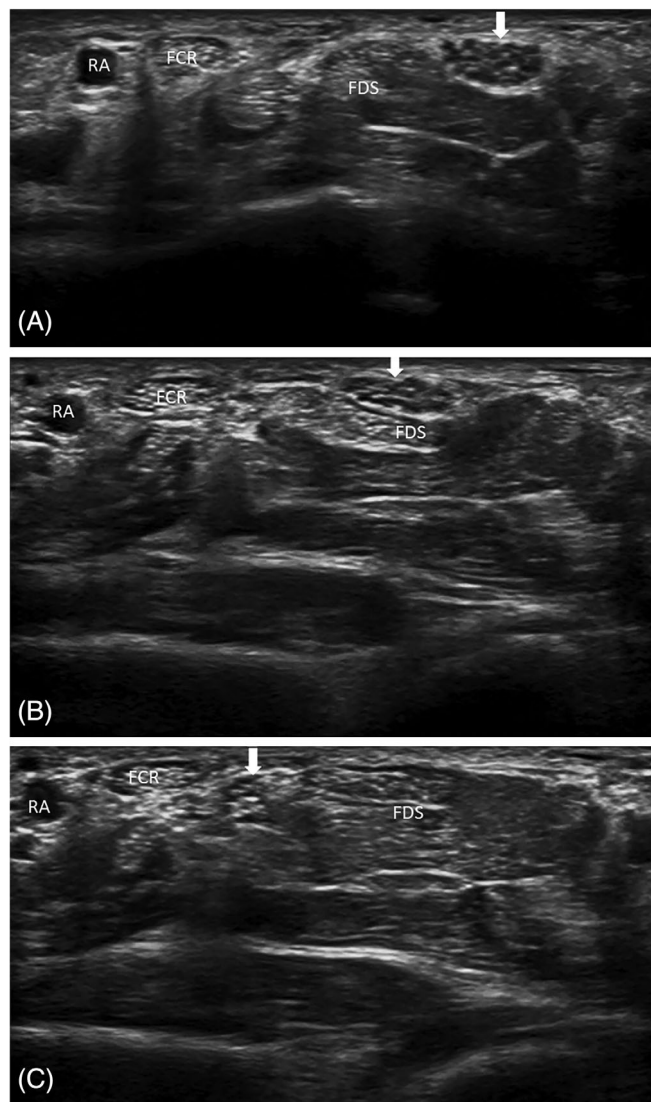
Axial sonograms show, during wrist extension, the median nerve (arrow) returns to its natural location (A–C). FCR, flexor carpi radialis; FDS, flexor digitorum superficialis; RA: radial artery
